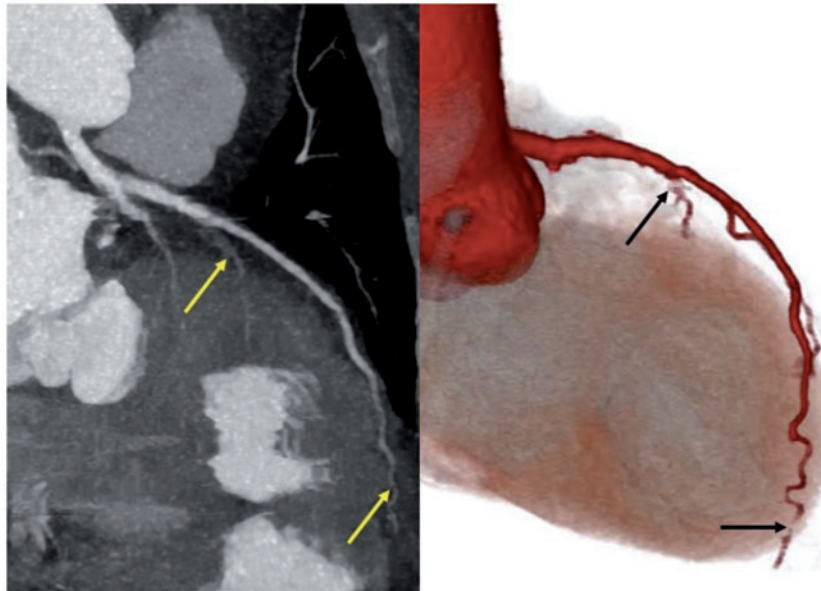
Curved planar formatted (left) and three dimensional volume rendered image (right) of coronary CT angiogram showing abrupt caliber changes in the septal branch (proximal yellow and black arrows) and distal portion of the left anterior descending artery (distal yellow and black arrows).
